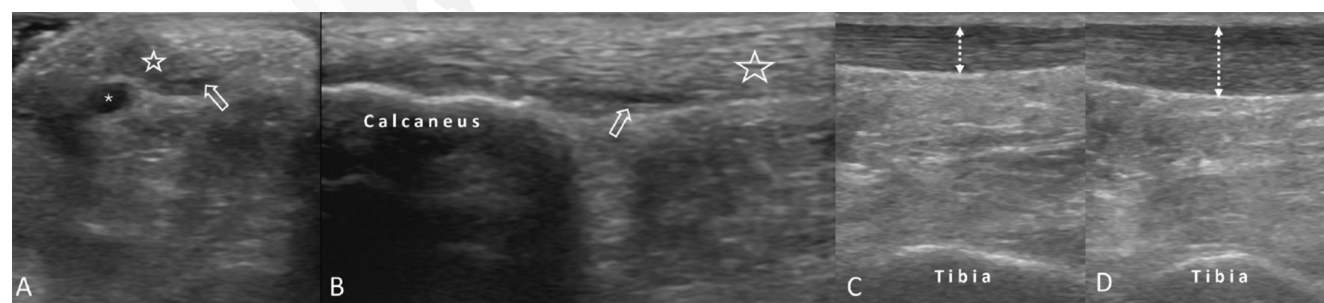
Axial (A) and longitudinal (B) ultrasound images demonstrate Achilles tendon (stars), ruptured area (arrows) and a small ganglion cyst (asterisk). Comparative longitudinal ultrasound images (C, D) show the swollen Achilles tendon on the symptomatic side (D)
